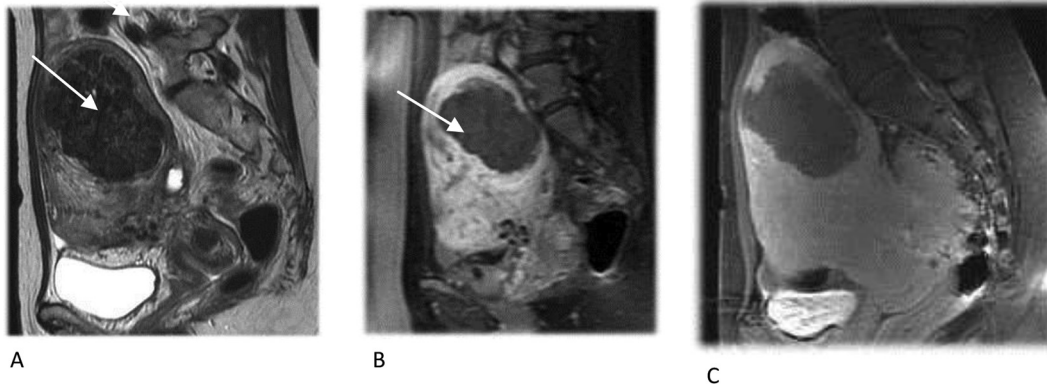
(A) Pretreatment T2-weighted sagittal image of a 47-year-old woman demonstrating one uterine fibroid (arrow) measuring about 150.2 mL (volume). Her SSS and UFS-QOL is 53.1 and 29.3, respectively. (B) The posttreatment enhanced T1-weighted image of the patient demonstrating the resulting NPV ratio (66.7%). The low signal intensity area (arrow) is indicative of the posttreatment necrotic area. (C) The 6-month follow-up enhanced T1-weighted image demonstrating that the volume of fibroid decreased to 89.3 mL. The volume decrease rate is 40.5%. The SSS and QOL is 37 and 61, respectively. The improvement of SSS and UFS-QOL is 16.1 and 31.7, respectively. NPV = nonperfused volume; SSS = Symptom Severity Score; UFS-QOL = Uterine Fibroid Symptoms and Quality of Life Questionnaire.
